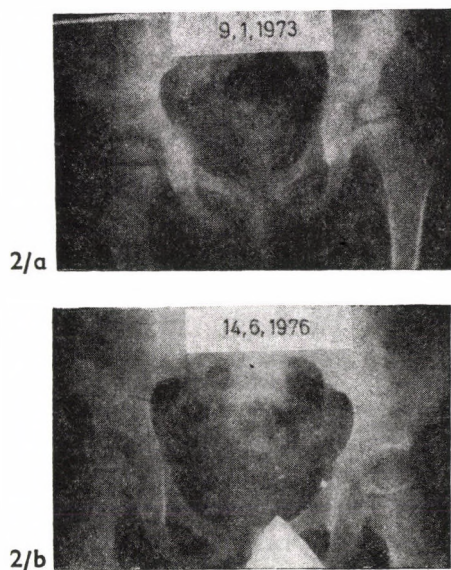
a. Roentgenogram of a 3 years old child. Subluxation on the left side. b. 3 years after open adductor tenotomy. On the left side: normal relations, subluxation on the right side
